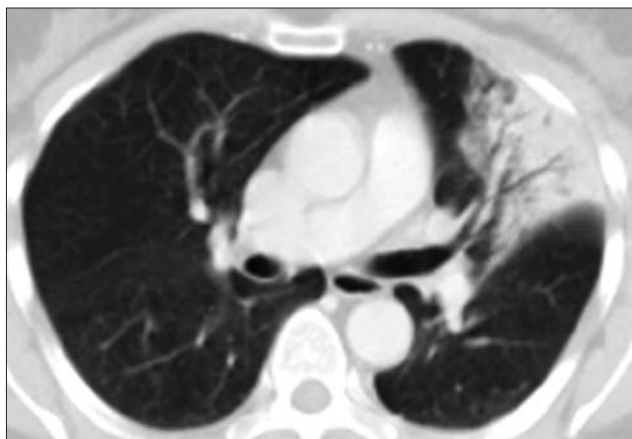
Thorax CT obtained due to fever and malaise in a patient who underwent radiotherapy for breast cancer 1 month ago shows consolidation in the lingular segment of the left upper lobe.
